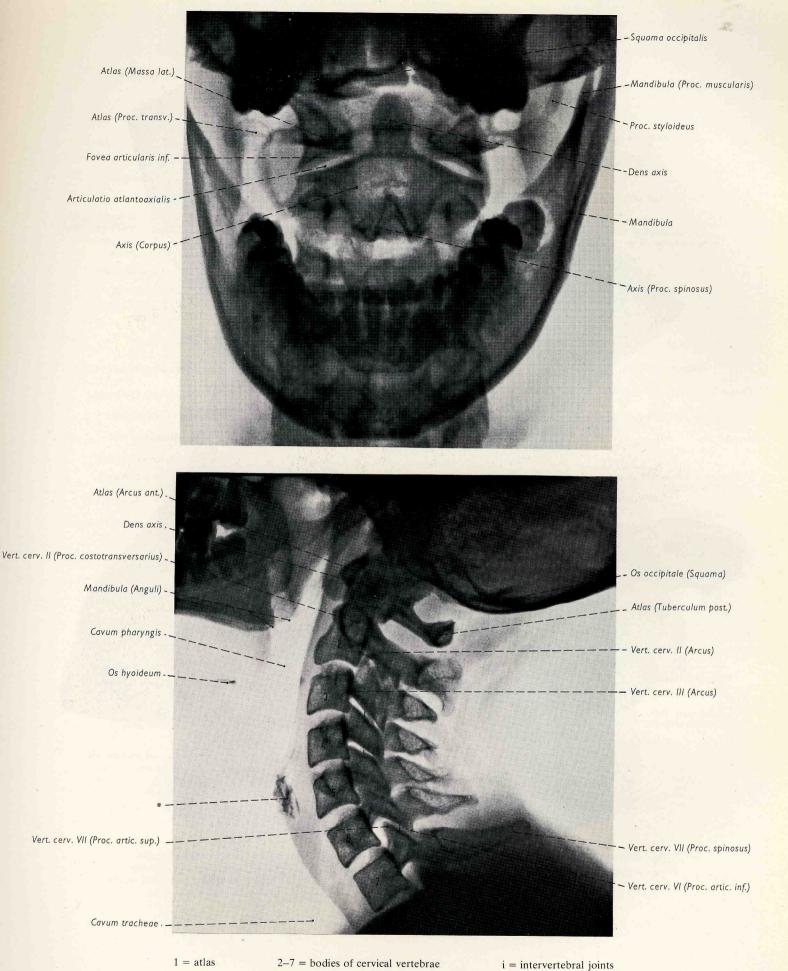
(Top) Roentgenogram of cranial end of cervical vertebral column, anteroposterior view through mouth (L. Wicke, Vienna).
